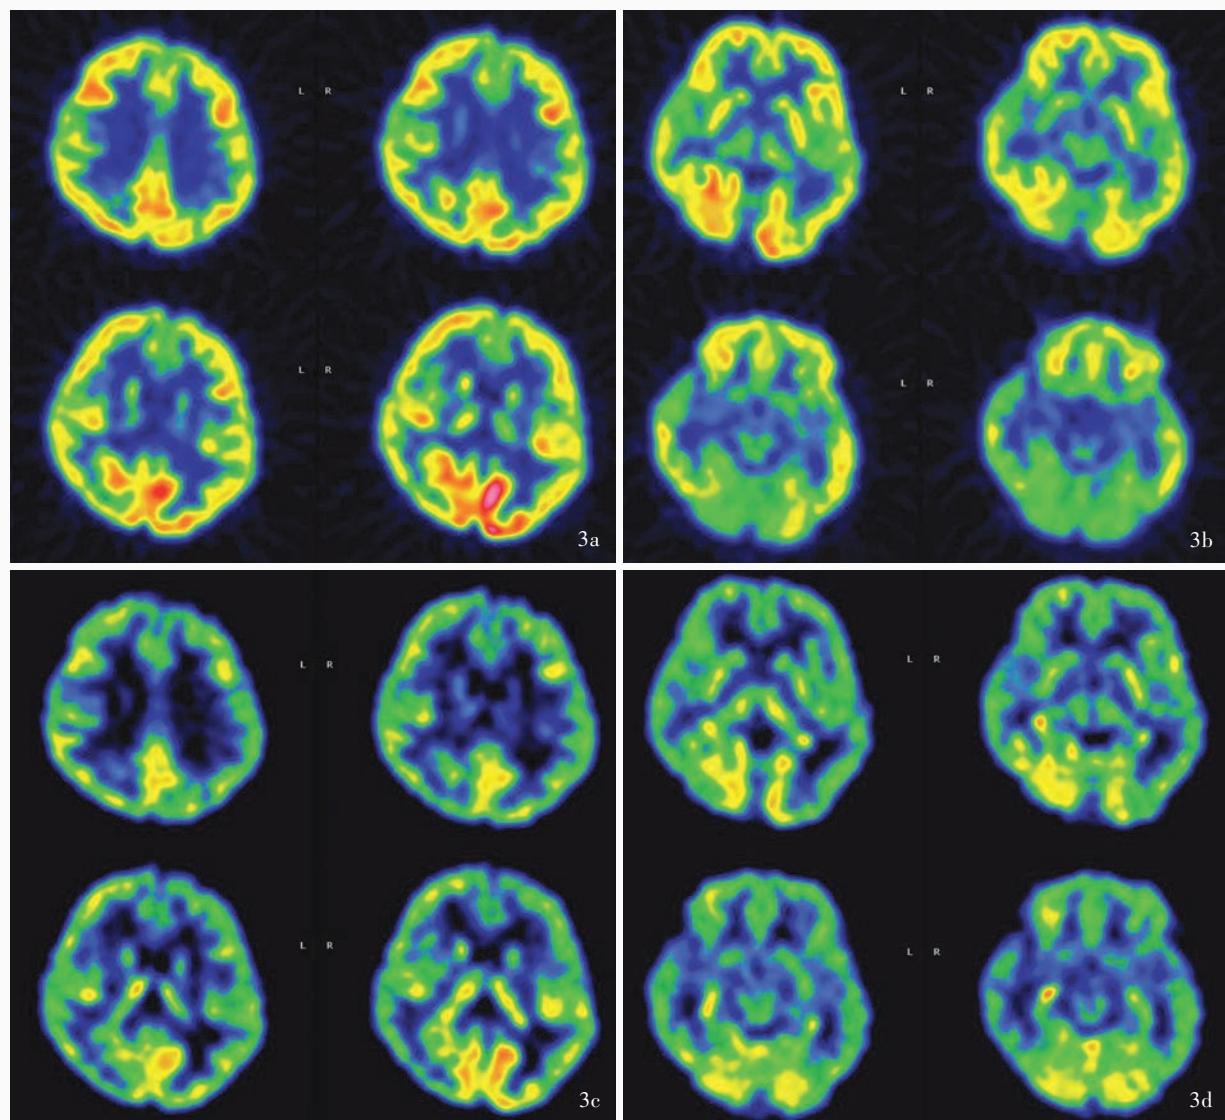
头部PET-CT检查所见 3a 右侧枕叶局部¹⁸F-FDG代谢浓集程度明显升高(红色区域所示),与邻近皮质近似 3b 双侧颞叶外侧皮质¹⁸F-FDG浓集程度弥漫性降低(蓝色区域所示),无明显偏侧;双侧颞叶内侧皮质海马区¹⁸F-FDG浓集程度未见异常 3c 右侧枕叶局部血流灌注明显升高(红色区域所示) 3d 右侧海马区血流灌注较对侧升高(红色区域所示)
